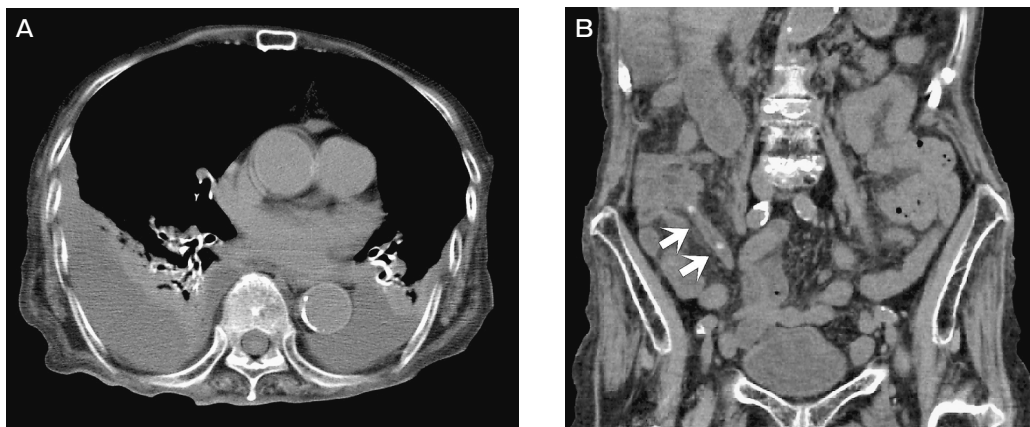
Computed tomography findings. A, Bilateral pleural effusion and atelectasis; B, A swollen appendix with a thickened wall containing an appendicolith (white arrow).
